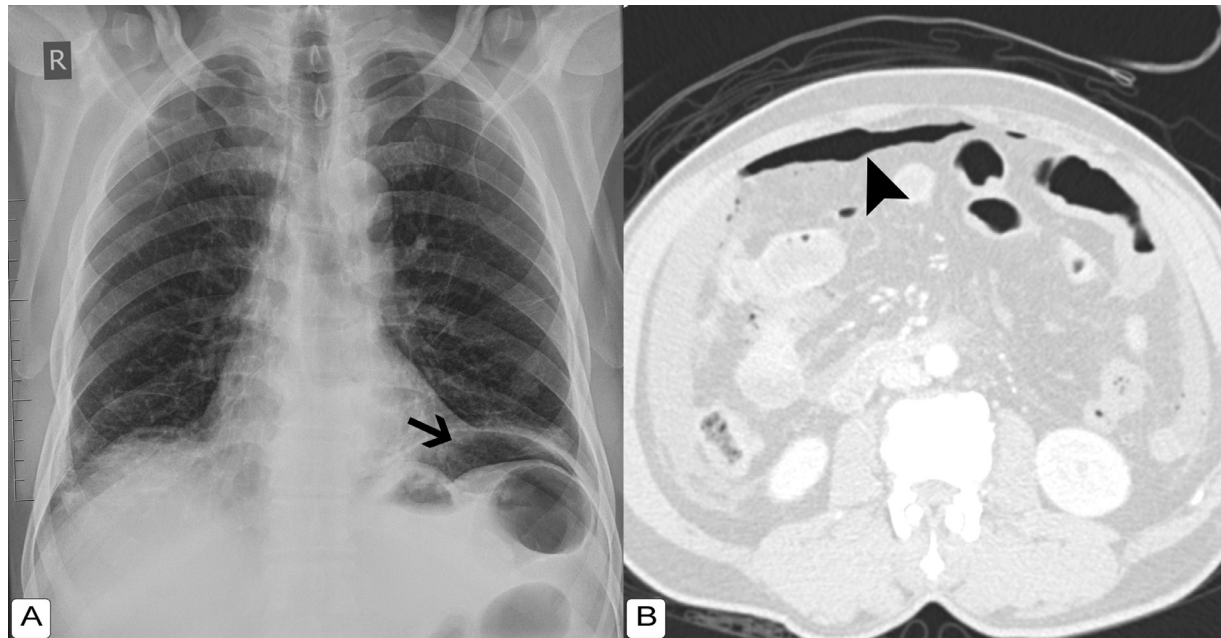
(A) Plain chest radiograph showing free air under the left hemidiaphragm (arrow). (B) Axial section of CT abdomen showing free air along the anterior abdomen [arrowhead].
